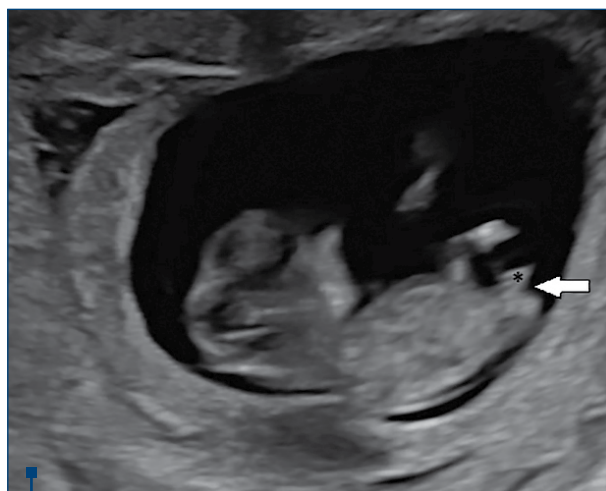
Two-dimensional ultrasonographic image exemplifying the sagittal sign in a 10+1 weeks female fetus. Note the asterisk indicating the genital tubercle pointing caudally and the white arrow indicating the caudal notch. Source: R.E. Bohiltea – personal collection
